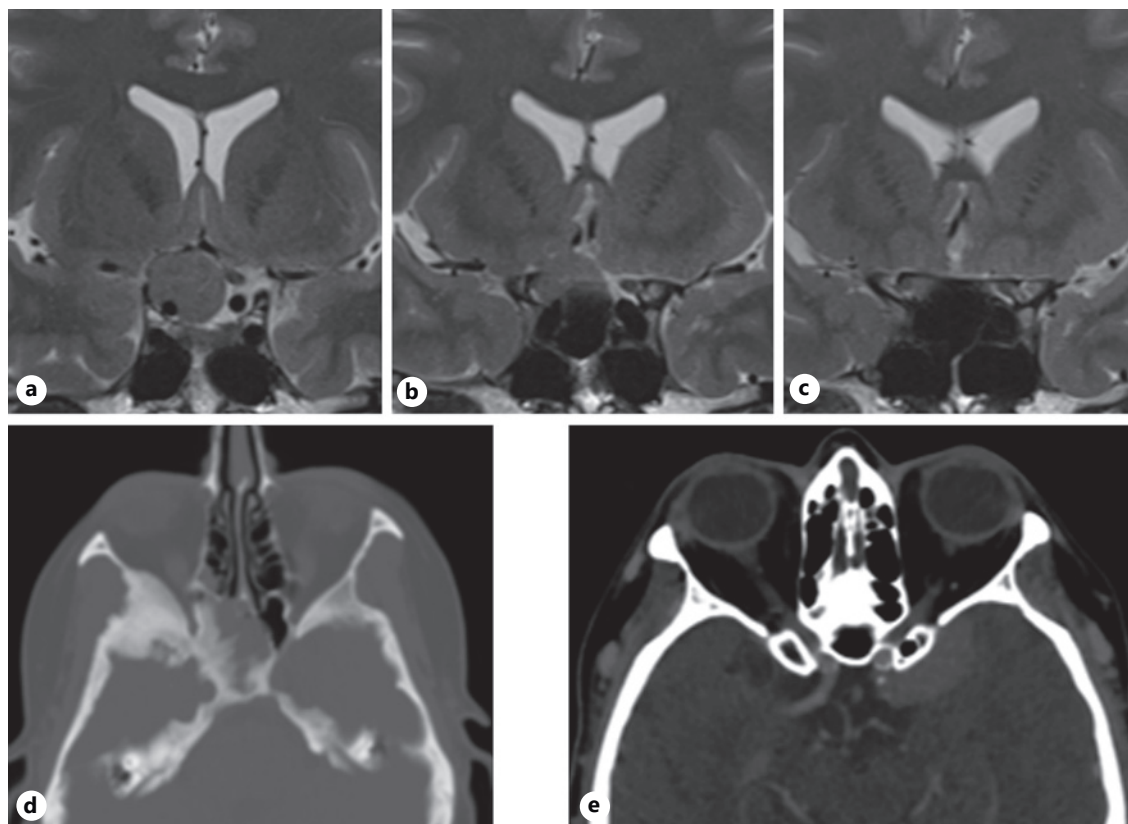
Interest of 3-T T2-weighted coronal MRI (a–c) showing the relationship between tuberculum sellae meningiomas, ON, and optic canal invasion. Preoperative CT scan displaying an osteoma (d) as pneumatization of the anterior clinoid process and the different sinuses (e).
